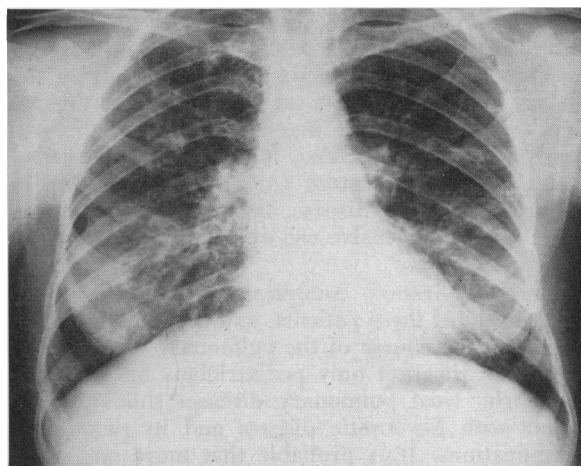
X-ray film of chest taken October 21, 1957, after two weeks of intermittent positive pressure breathing therapy three times daily, along with antibiotics. This film was interpreted as showing improvement. There was no change from then to the most recent film taken February 21, 1958.
